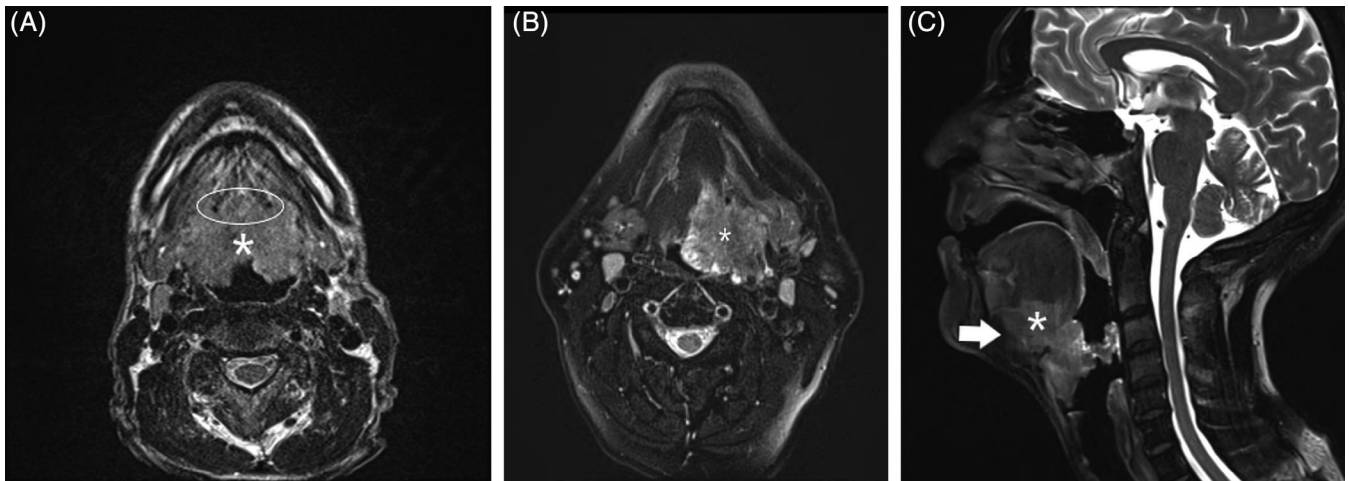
MR images demonstrate absolute contraindications for transoral robotic surgery of the tongue base. A, Axial T2-weighted MR image demonstrates an extensive tongue base mass (*) which encases the bilateral lingual arteries (circled). B, Axial T2-weighted MR image demonstrates a left tongue base carcinoma which extends anteriorly and left laterally with involvement of the left genioglossus and hyoglossus musculature. Tumors with such a degree of extension carry a high risk for aspiration post-resection. C, Sagittal T2-weighted MR image demonstrates a tongue base carcinoma (*) which undercuts the tongue parenchyma (arrow), leaving the tongue tissues at risk for devascularization following a surgical resection
